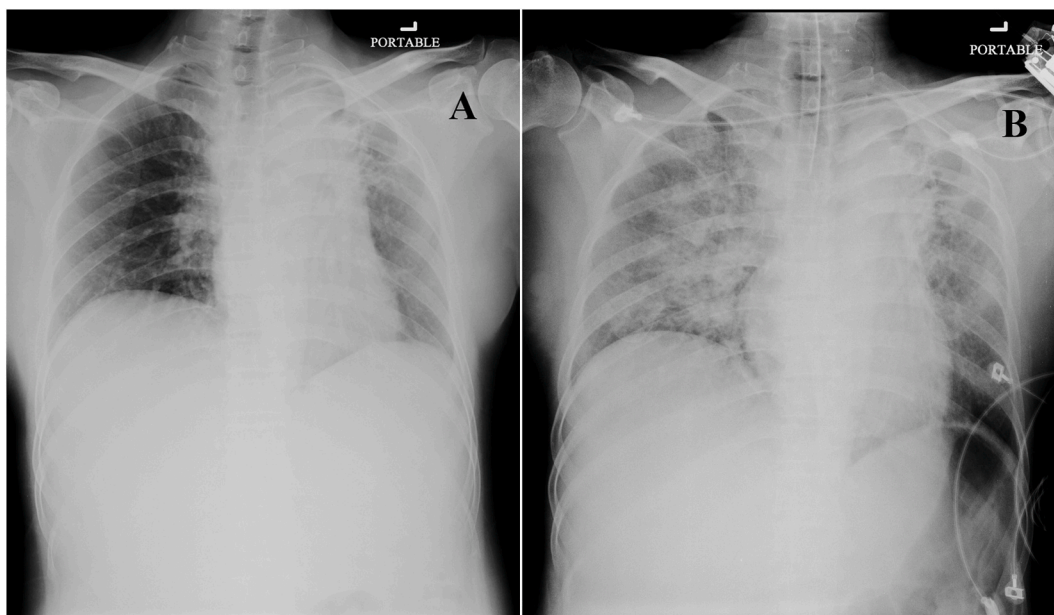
A chest radiograph 12 hours before (A) hypertensive crisis showed decreased lung volume and fibrosis in the left upper lung field corresponding with a history of pulmonary tuberculosis. And a chest radiograph 6 hours after (B) hypertensive crisis showed a rapid change in bilateral patchy alveolar infiltrates compatible with acute pulmonary edema.
